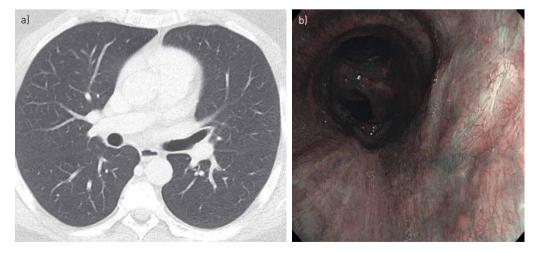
Follow-up at 2 years: a) computed tomography scan and b) bronchoscopy with narrow band imaging (NBI) to check for local recurrence. NBI uses a unique filter to select light wavelengths that are preferentially absorbed by haemoglobin, thereby permitting superior microvasculature detection compared with conventional bronchoscopy [62]. As angiogenesis occurs preferentially in dysplastic or neoplastic lesions, NBI aids in early assessment of local recurrence.
